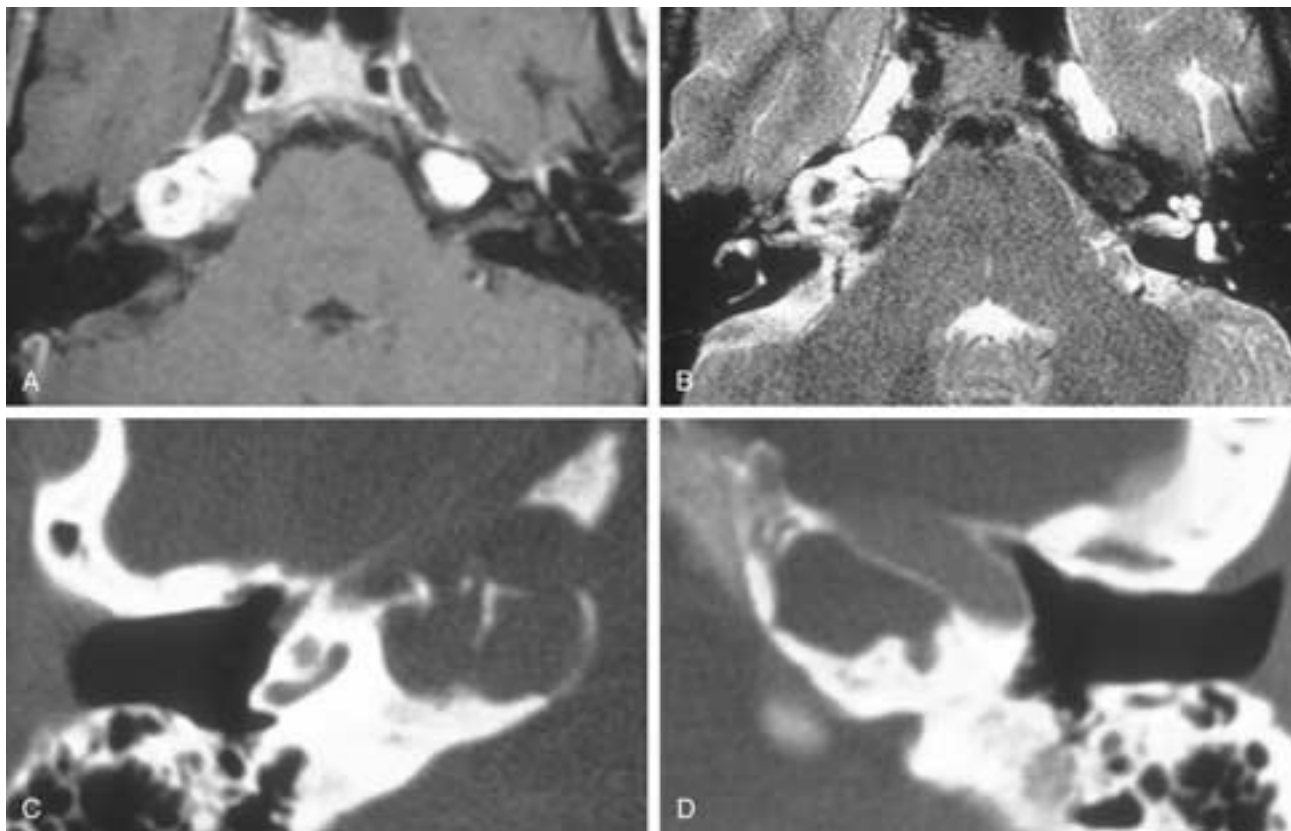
Bilateral petrous apex cholesterol granuloma. A, T1-weighted image shows ovoid, smoothly marginated, expansile (especially on the right side) lesions of both petrous apices with typical high signal intensity. B, T2-weighted image. The granulomas have heterogeneous signal intensity with a peripheral hypointense rim due to expanded cortical bone. C and D, CT bone window images. Cystic, lobulated lesions are seen bilaterally. Granuloma on the right side is more expansile and also has eroded the medial wall of the carotid canal.
